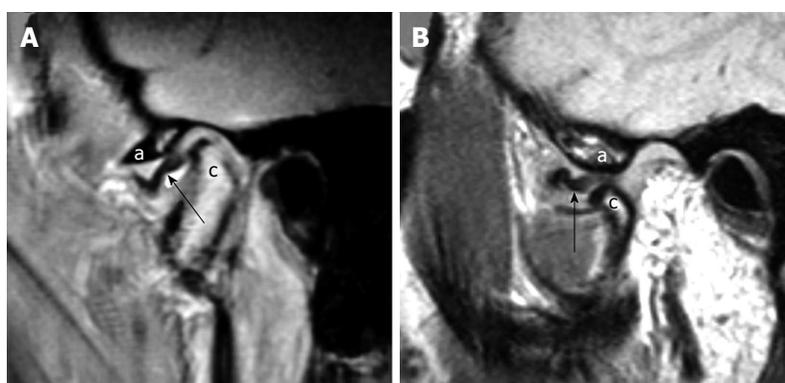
Anterior displacement with no reduction. A: Sagittal proton density weighted magnetic resonance imaging (MRI) in the closed mouth position demonstrates anterior displacement of the disk (arrow) related to the articular eminence (the letter, a) and anterior to the mandibular condyle (the letter, c); B: Sagittal proton density weighted MRI in the open mouth position demonstrates no reduction of the disk (arrow) between the articular eminence (the letter, a) and the mandibular condyle (the letter, c).
